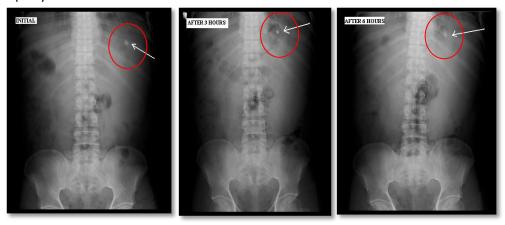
X-Ray image showing the BaSO4-loaded floating tablet prepared with PEO and Olibanum.
